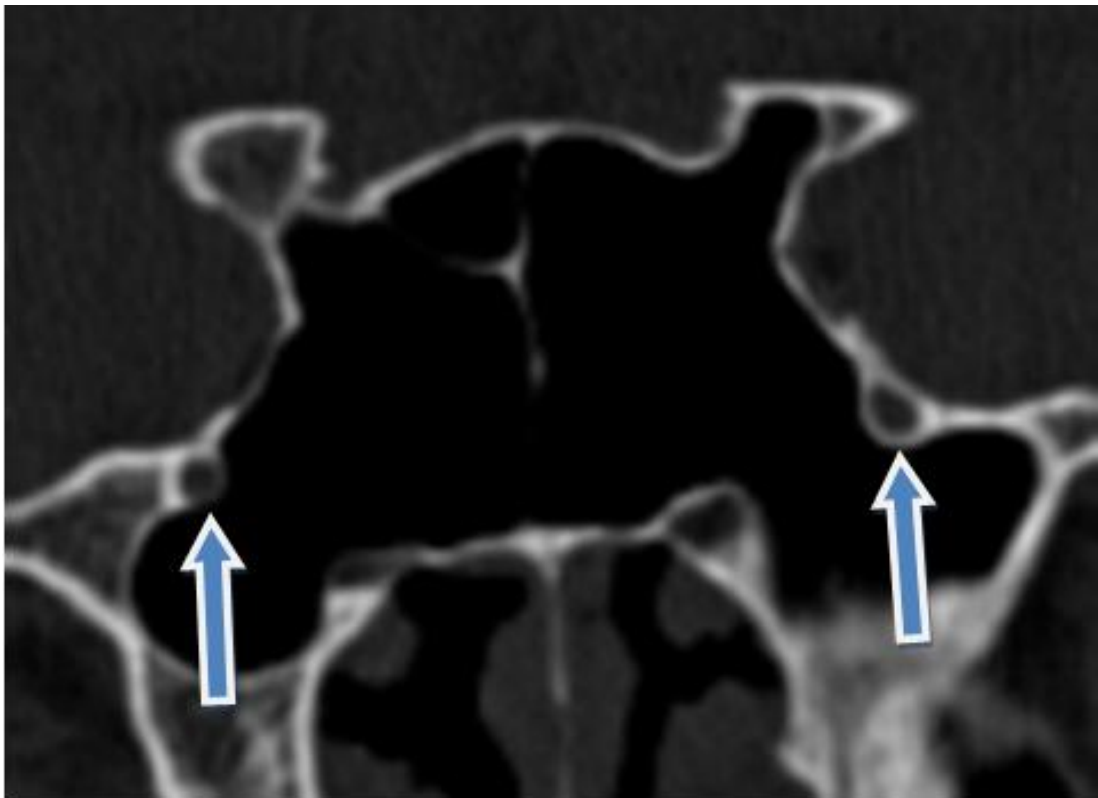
CT coronal section of sphenoid sinus showing protrusion of bilateral maxillary nerves (arrows).
